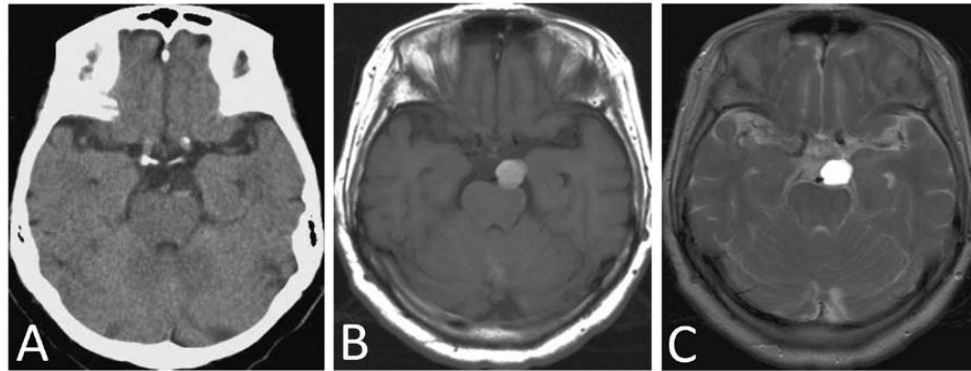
A) Axial unenhanced CT at presentation, showing a cystic lesion in the left crural cistern that is isodense to the cisternal space. B, C) Axial unenhanced MRI showing cystic and homogeneous mass. T_1 -weighted imaging (B) shows a hyperintense mass. T_2 -weighted imaging (C) shows extreme hyperintensity compared to brainstem. Tiny high-intensity niveau in this mass suggest hemorrhage in the cyst.
